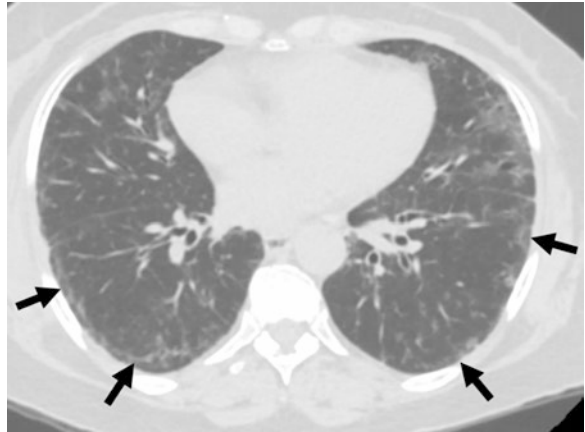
Axial chest CT from a patient with COVID-19 pneumonia. There are subpleural curvilinear lines in both lungs (arrows)
